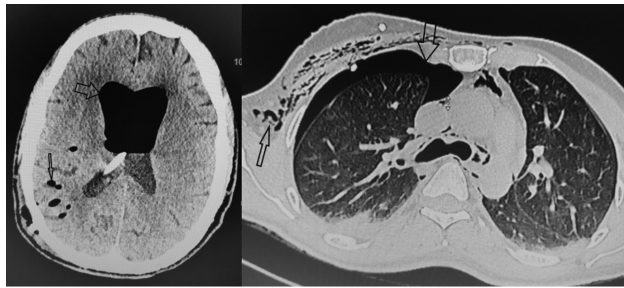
Computed tomographic (CT) scan brain showing pneumocephalus (thin arrow) and pneumoventricle (thick arrow). Shunt tube is seen in situ. CT thorax showing right pneumothorax (thick arrow) with subcutaneous emphysematous changes (thin arrow). Pleural end of shunt tube can be seen at 10 o'clock position in right hemithorax.
